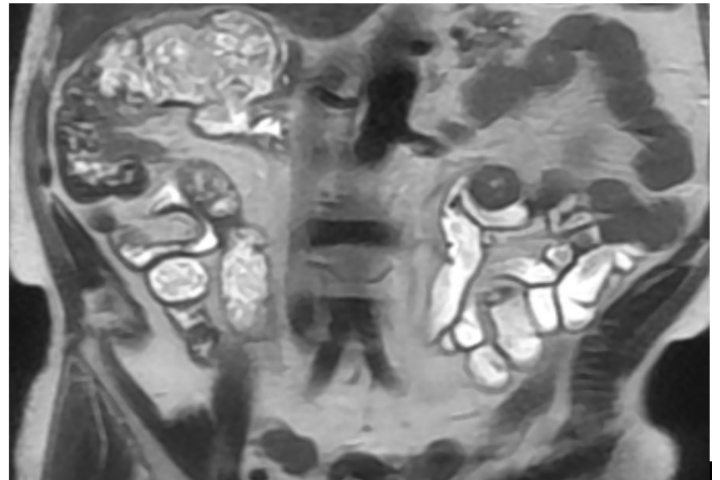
T2 weighted MRI coronal acquisition, the tumour demonstrates high signal consistent with mucinous pathology
